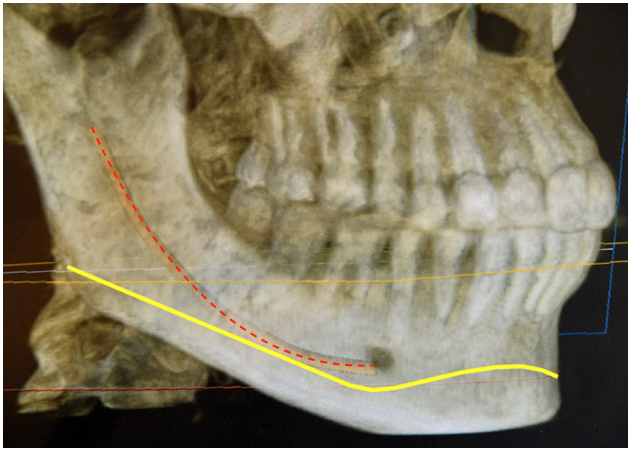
3D reconstruction of a mandibular cone beam, IAN (–) and osteotomy tracking.
